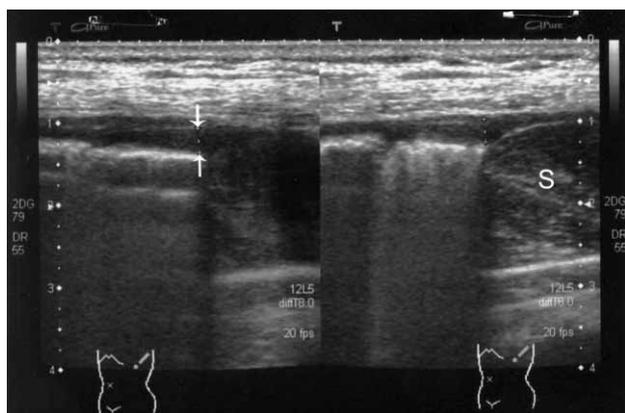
Examination of the left pleural space in »leaning on the elbow« position showing a wedge shaped collection of physiological pleural fluid (between white arrows). This is a typical image of the individual with sonographically »wet« pleural space. S=spleen.
